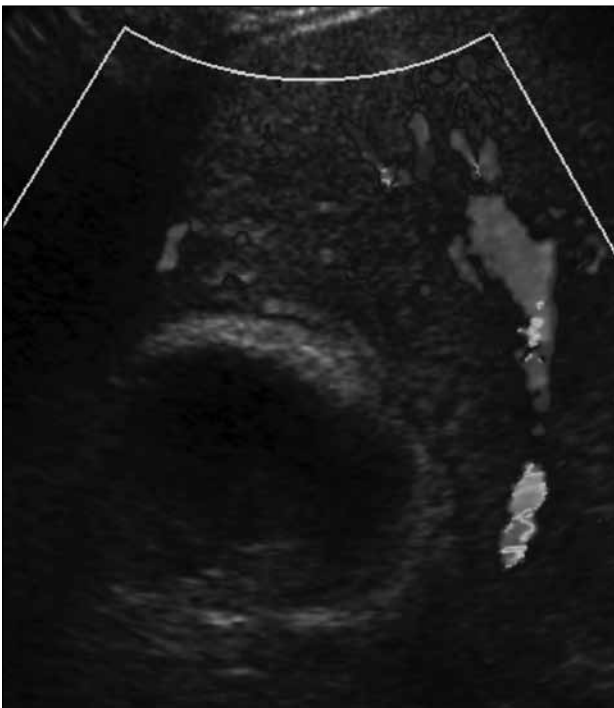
Ultrasonography showing liver haematoma with interval decrease in size.
